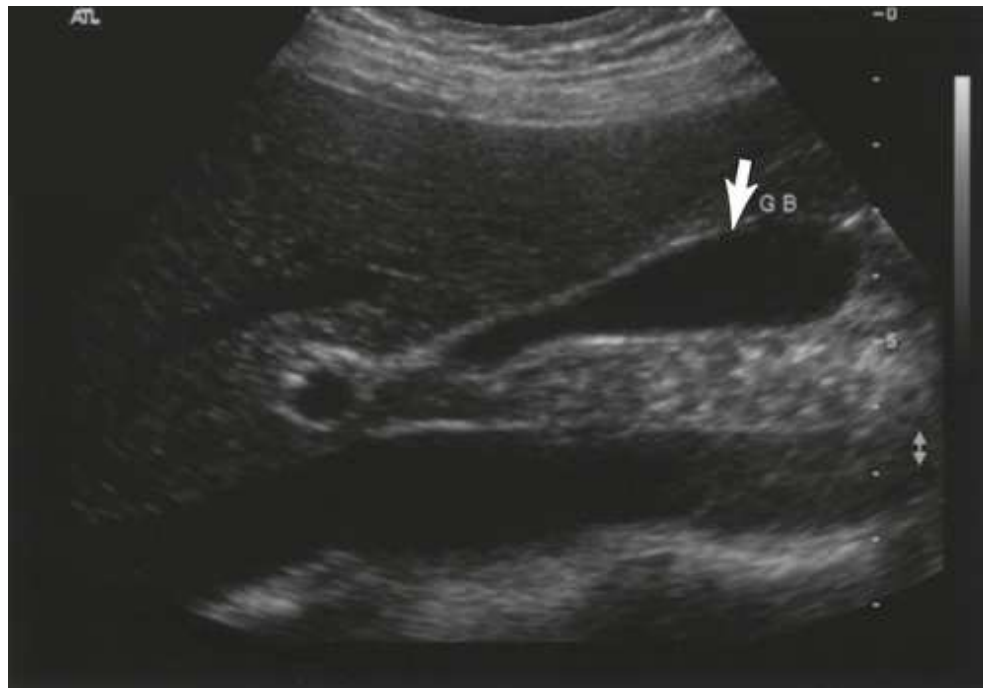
Sagittal sonogram of normal gallbladder (GB).
